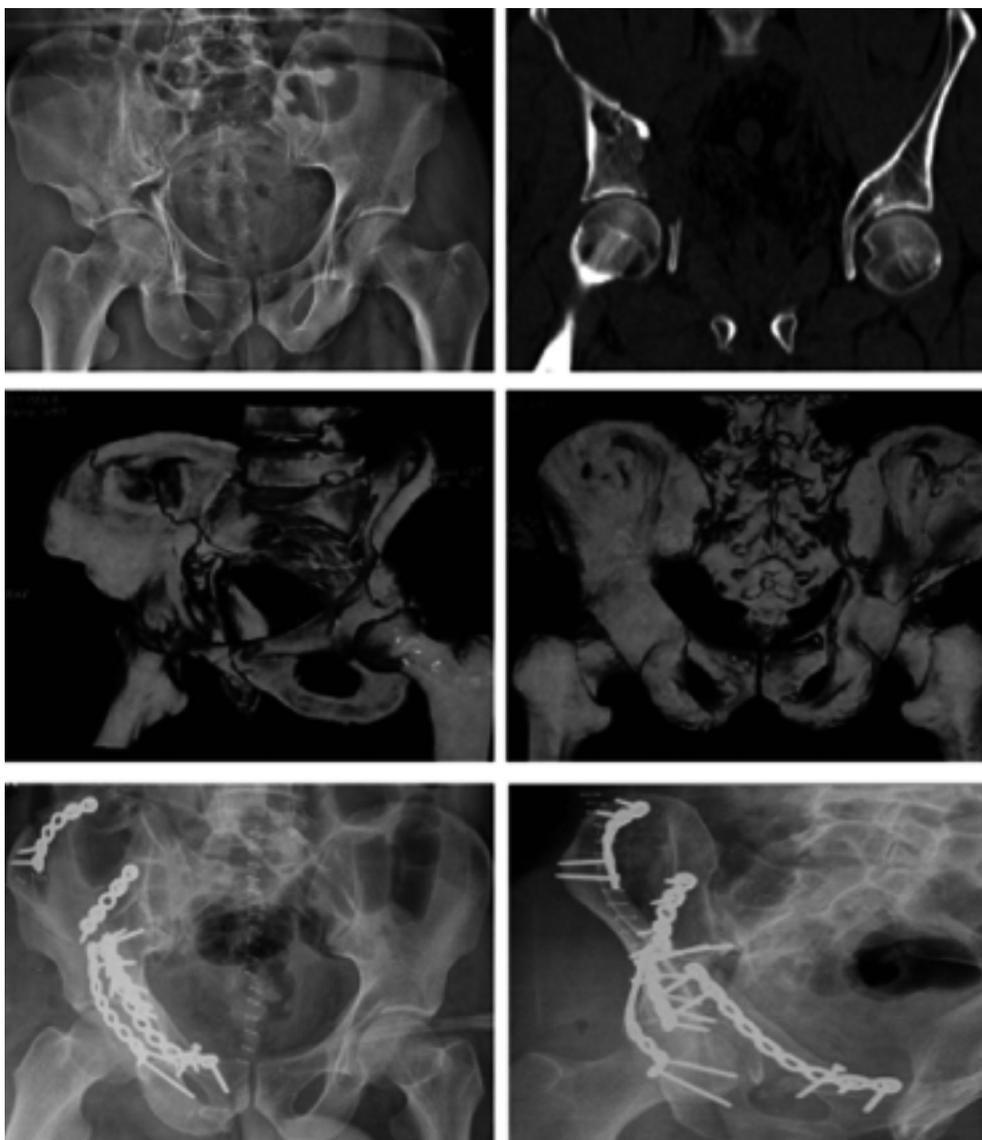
A 32-year-old female had a right acetabular fracture involving the anterior and posterior columns and underwent open reduction and internal fixation via anterior and posterior approaches. Postoperative X-ray shows anatomical reduction of the acetabulum
